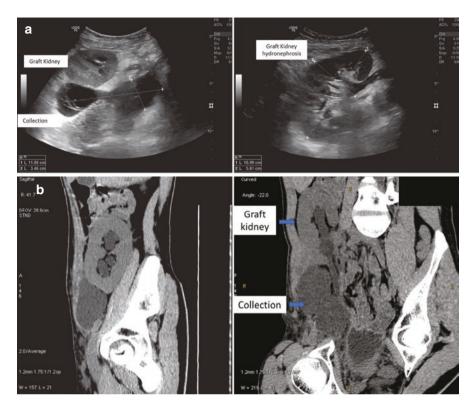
(a) Ultrasonography depicting peri-graft collection leading to graft kidney hydronephrosis. (b) Plain CT scan showing perigraft collection which can be aspirated for analysis. The resultant graft hydronephrosis can also be well appreciated in the first image
